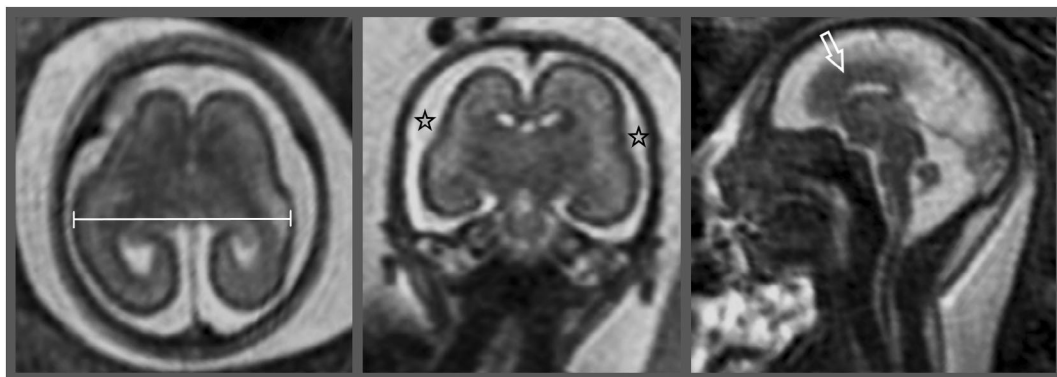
Microcephaly, 21 GW. (A) Axial T2-weighted image shows reduced biparietal diameter (line). (B) Coronal T2-weighted image shows flattened, barely visible Sylvian fissures (stars). (C) sagittal T2-weighted image shows hypoplastic corpus callosum (white arrow)
